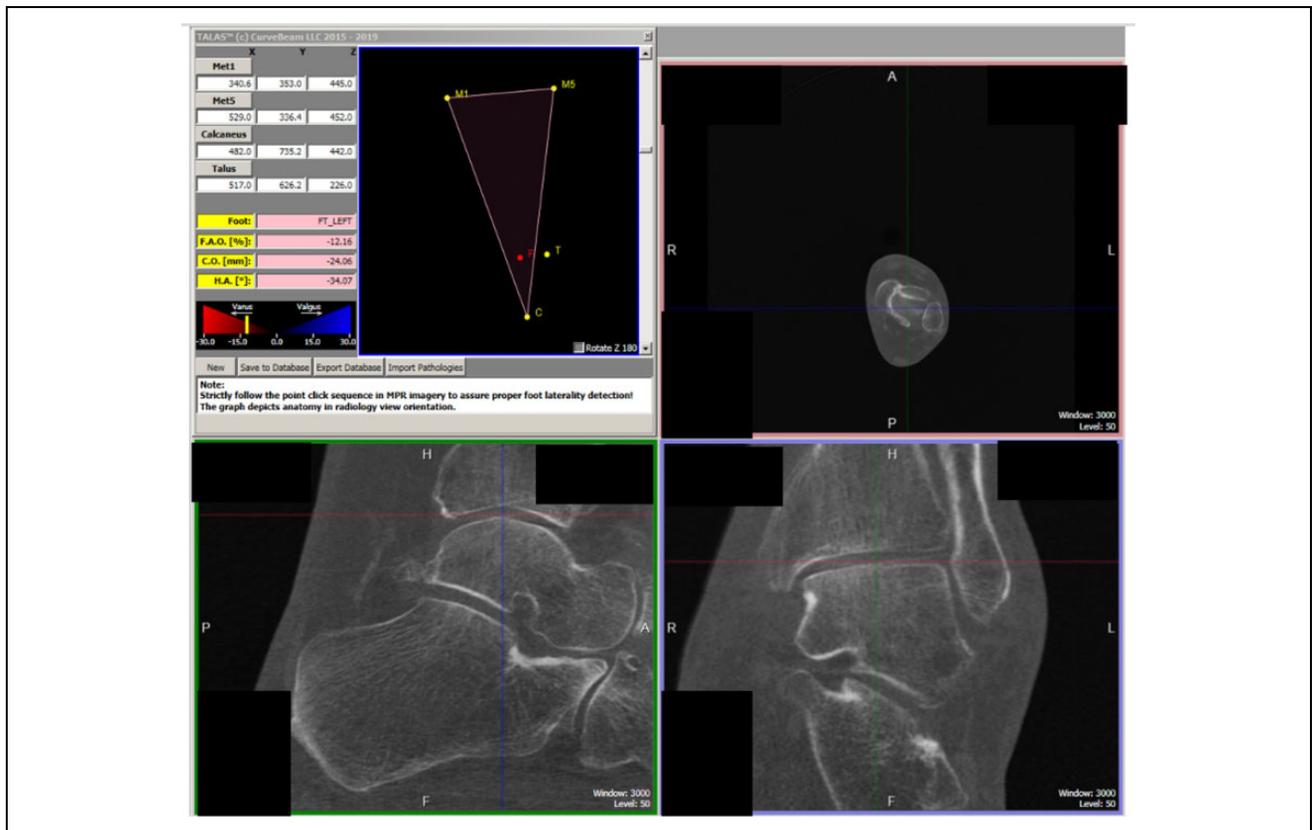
Example of calculation of foot ankle offset, calcaneal offset, and automated CT hindfoot alignment angle with the TALAS software (Curvebeam LLC). The top left box demonstrates the elements required to calculate these values, including M1 (first metatarsal weightbearing point), MS (fifth metatarsal weightbearing point), C (weightbearing calcaneus point), T (vertex of talar dome). 'F' is the calculated by the TALAS software and represents the center of the foot weightbearing surface. The inferior two boxes demonstrate how the vertex of the talar dome is determined by manual placement of x.y.z coordinates (green, red, and blue lines).
